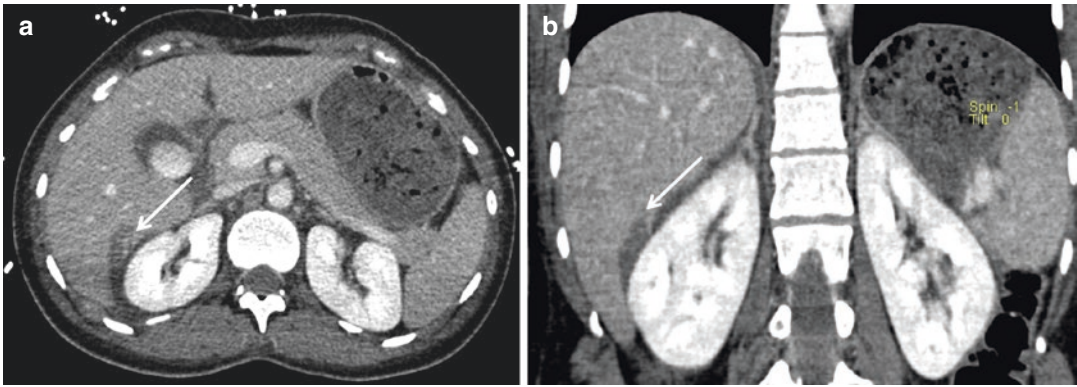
(a) Axial CT scan and (b) coronal reconstruction show the superficial hepatic laceration (*arrows*): extension is <1 cm deep
